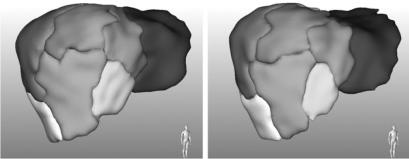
Example of drainage territories determined from the liver mask and the hepatic veins of the same potential donor on basis of CT (left) and MRI data (right).
